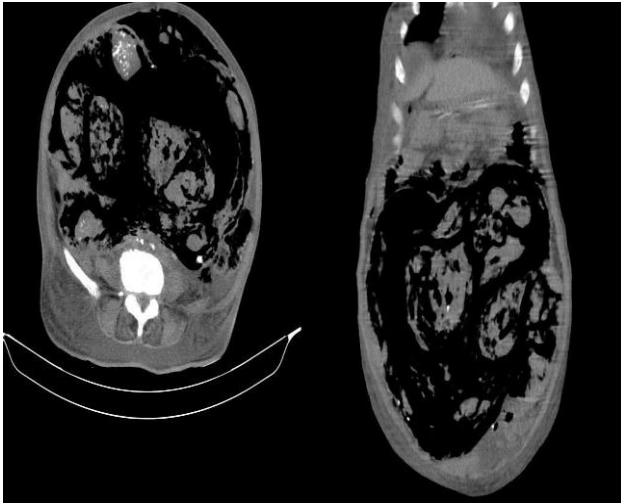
Plain axial & coronal CT sections showing mixed density lesion with multiple air pockets, calcific foci and soft tissue density areas. In coronal section extraluminal air pockets can also be seen
